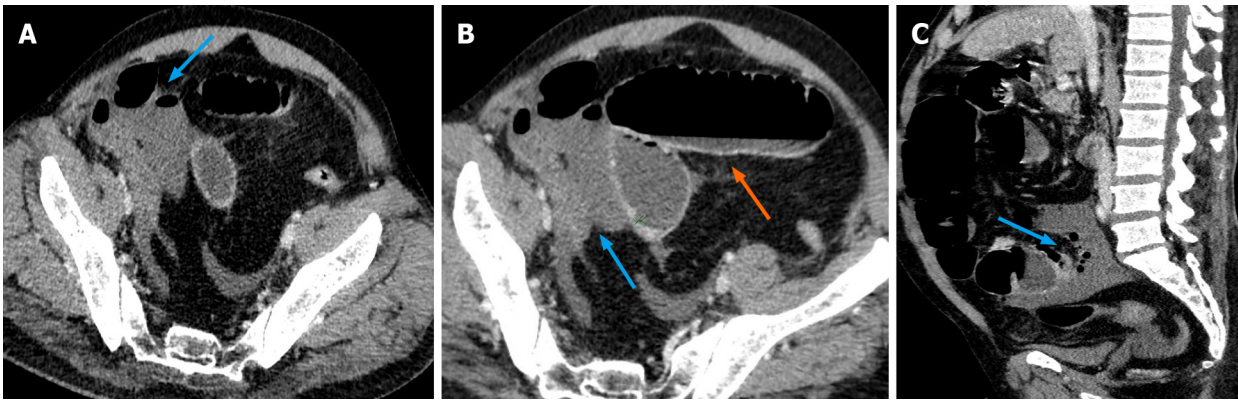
Small bowel ischemia detected on computed tomography mesenteric angiography study performed in a coronavirus disease 2019 patient presenting with severe abdominal pain and abdominal distension. A and B: Axial contrast enhanced computed tomography (CT) images of the abdomen and pelvis; C: Sagittal contrast enhanced CT images of the abdomen and pelvis, showing dilated distal ileal loops in the right iliac fossa with non-enhancing, barely discernible walls suggestive of bowel gangrene (blue arrows in A, B, and C). The proximal small bowel loops appear dilated with air-fluid levels within, suggestive of stasis (orange arrow in B).
